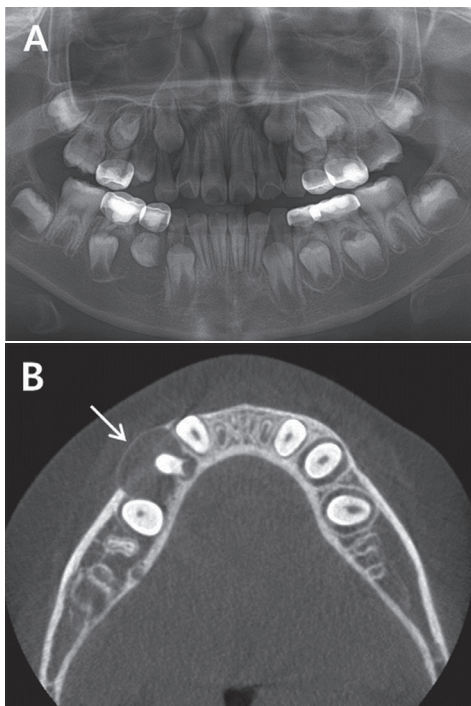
Panoramic view (A) shows a cystic lesion resolving at the root of the right lower first primary molar. Buccal bony expansion (white arrow) and lingually displaced succedaneous tooth germ were seen on the axial CT view (B).
